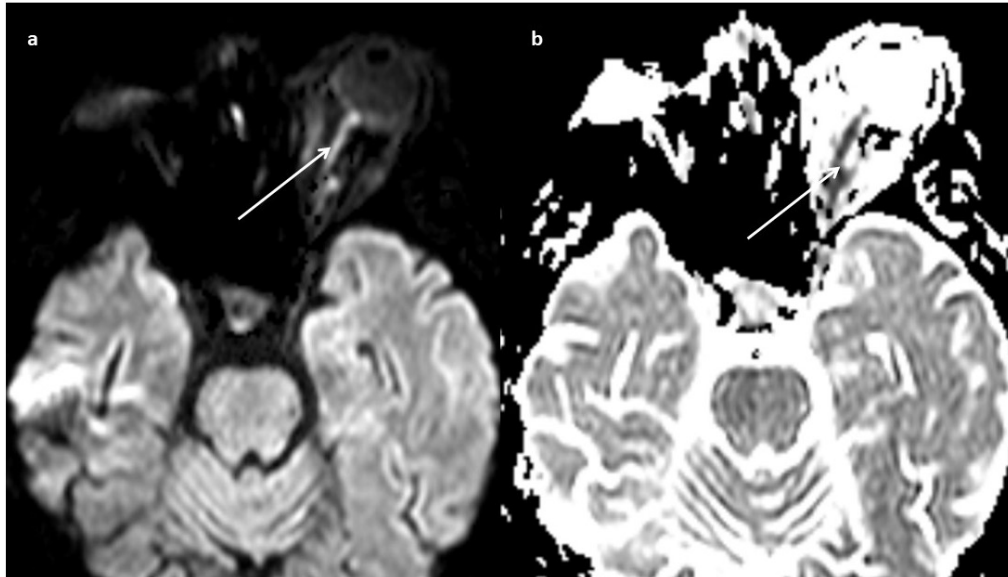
Axial MRI (a) DWI and (b) ADC map show proptosis of the left globe and restricted diffusion in the left optic nerve (white and black arrow).
